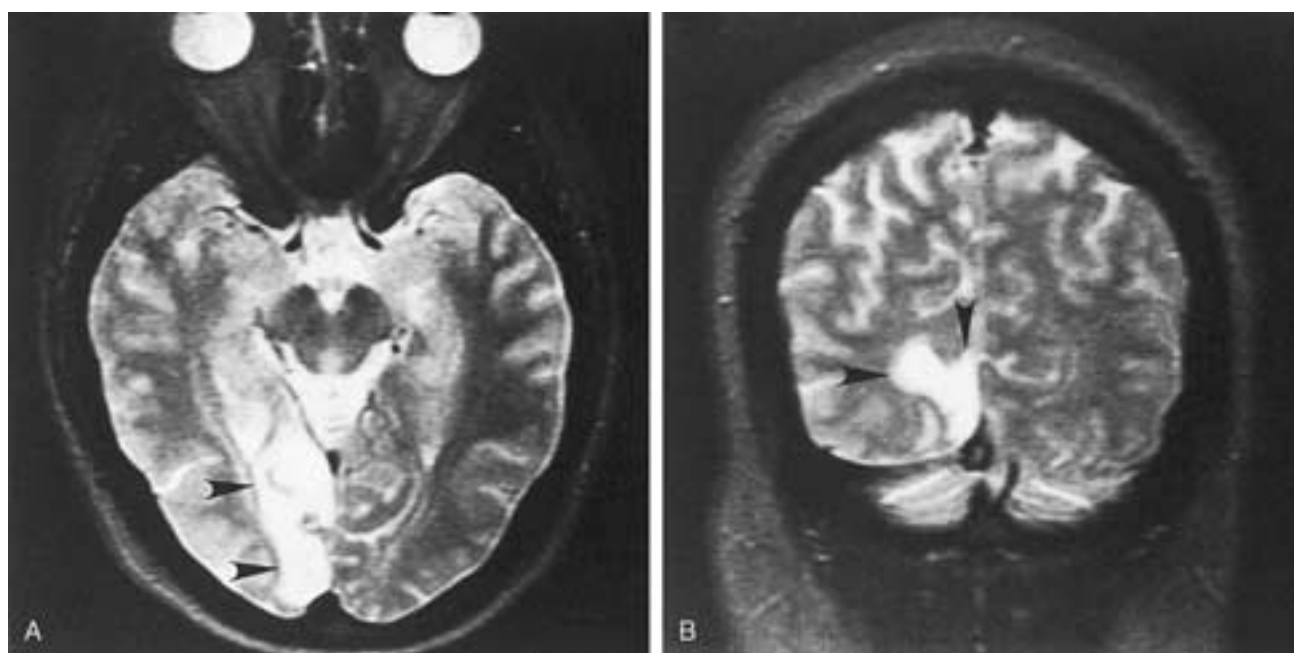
A, Axial T2-weighted image shows a high signal intensity occipital infarct (*arrowheads*). B, Coronal T2-weighted image. The infarct (*arrowheads*) lies below the calcarine fissure.
